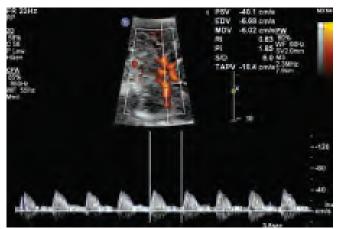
Appropriate PRF setting to avoid aliasing in pulsed Doppler waveform analysis
